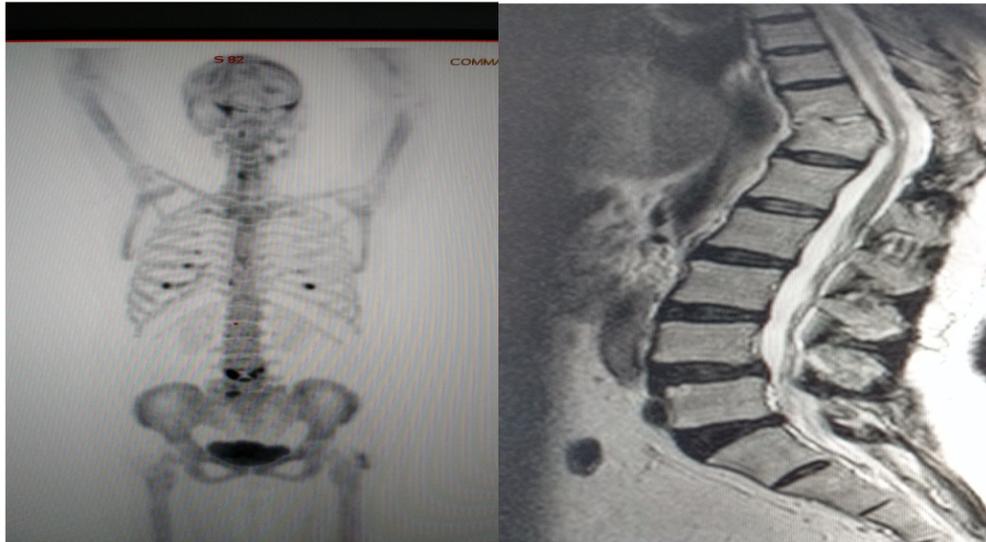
53 years old female patient of breast cancer. PET scan showed increase uptake in LV4. MRI revealed only compression fracture of DV12 and reduced IV disc space between D11-12.
